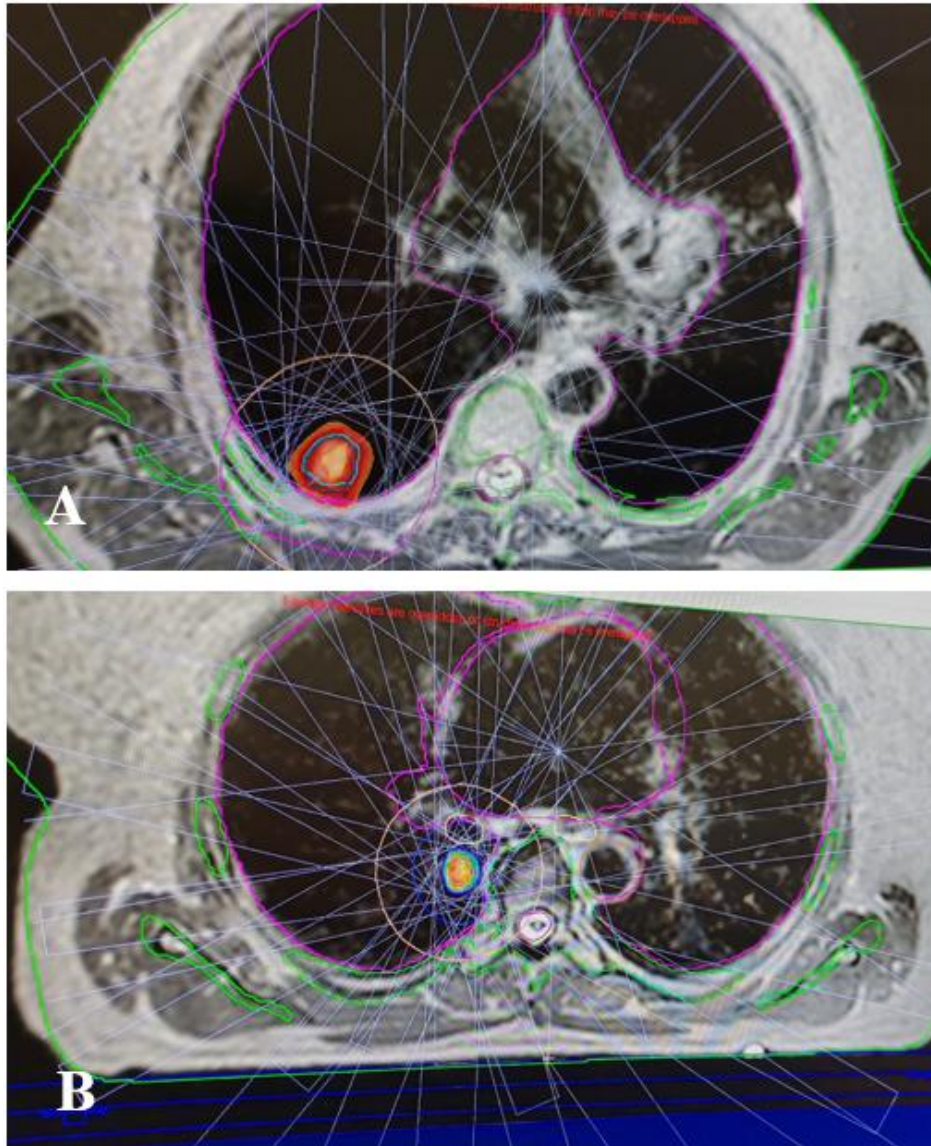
Lung SBRT MRI-LINAC plan field configuration: A—Case I (18 fields), B—Case II (15 fields)
